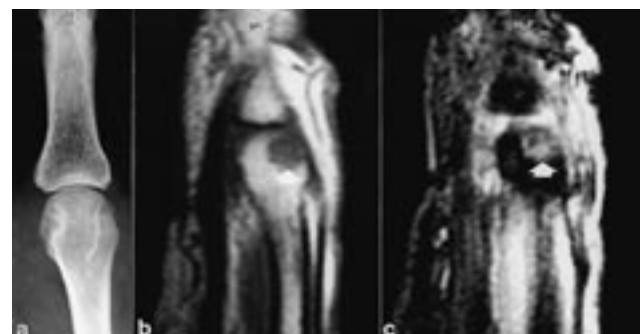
(a) The radiography of the III metacarpo-phalangeal joint does not show any abnormality. (b), (c) The MR images show a subchondral focal area of signal change (arrows) in the metacarpal epiphysis, hypointense in the T1W sagittal section (b) and hyperintense in the T2W (c).
